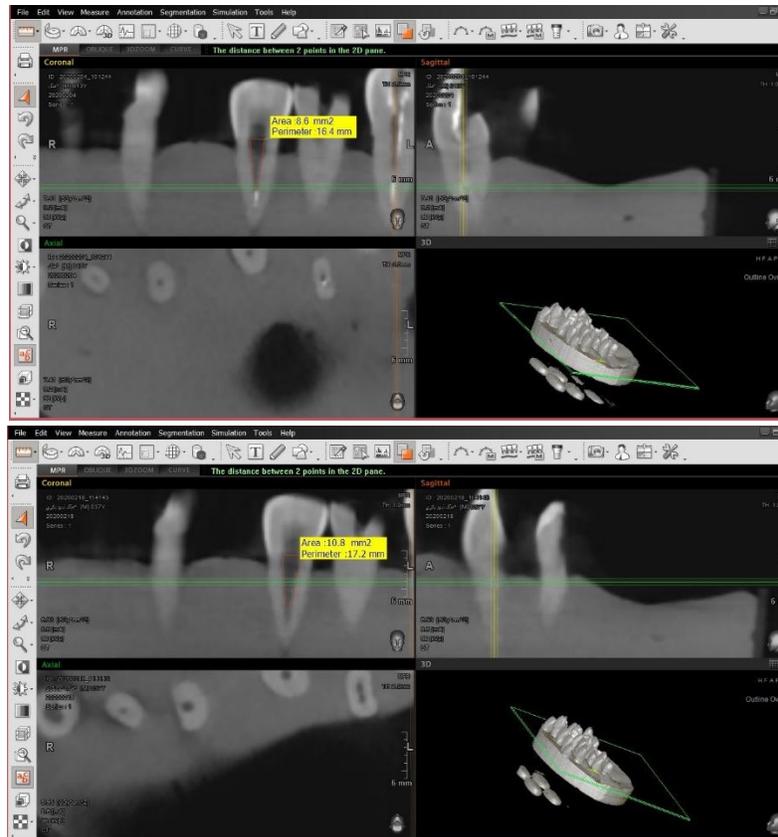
CBCT view before and after retrieval procedure.
